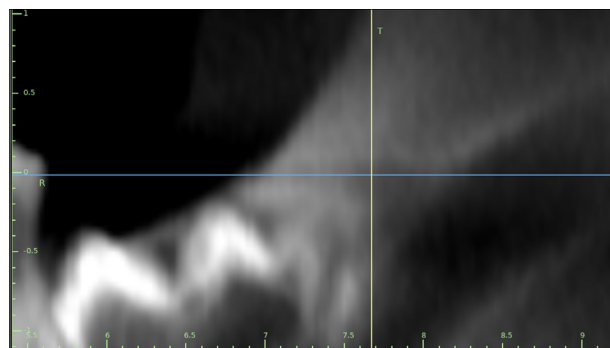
Representative 28-day postablation radiograph of tooth bud #18 (at crosshairs). Bone regeneration appears nearly complete. Photo credit: TriAgenics, Inc.
